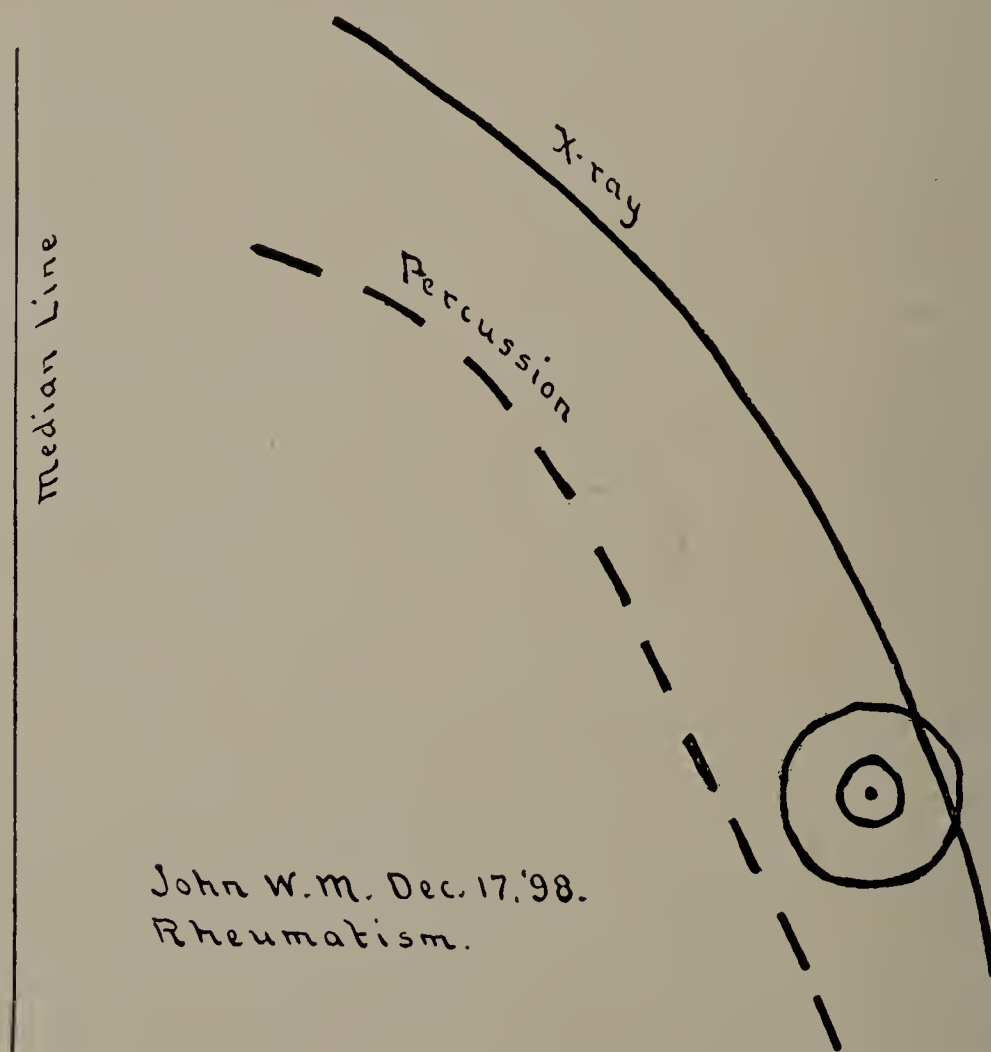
John W. M. December 17, 1899. X-ray tracing. Full line shows position of left border of heart; broken line, its position as determined by percussion. (Cut one-third life size.)
